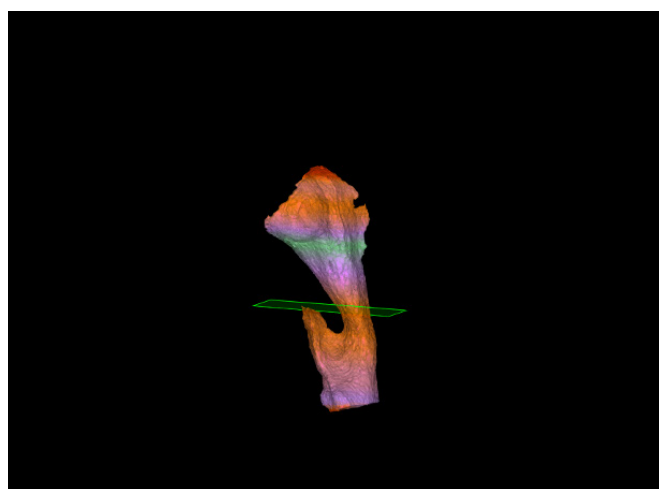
STL version of the total airway volume measured by CBCT.
